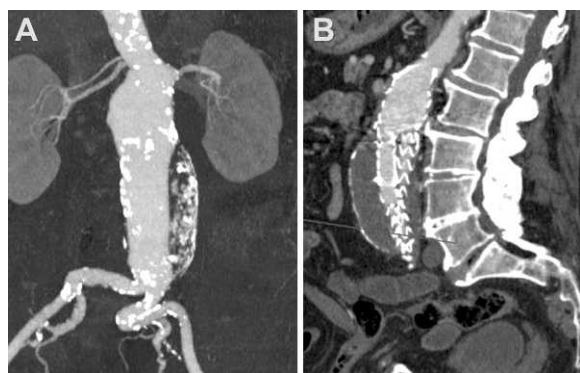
♦ (A) Volume-rendered CTA displaying a short flared infrarenal aortic neck; both renal artery origins are calcified with >60% stenosis of the left renal artery. (B) CTA 1 month after implantation of an Endurant stent-graft. Oversizing >30% and coil deployment has ensured good apposition of the stent-graft in this case along the short flared proximal sealing zone, but a mild inversion of the suprarenal stent can be identified, with no adverse effect.
